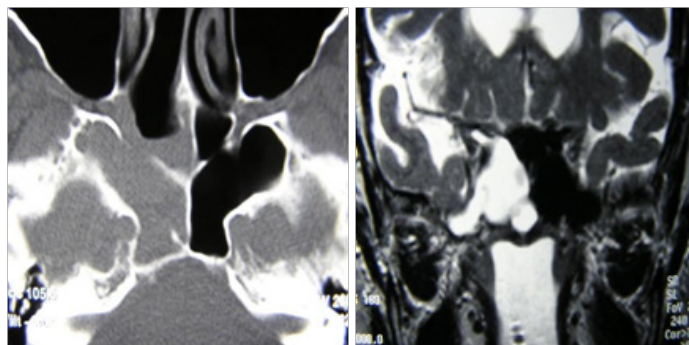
Lateral Sphenoid wall MC (Sternberg canal) Enhanced CT Scan and MRI.
